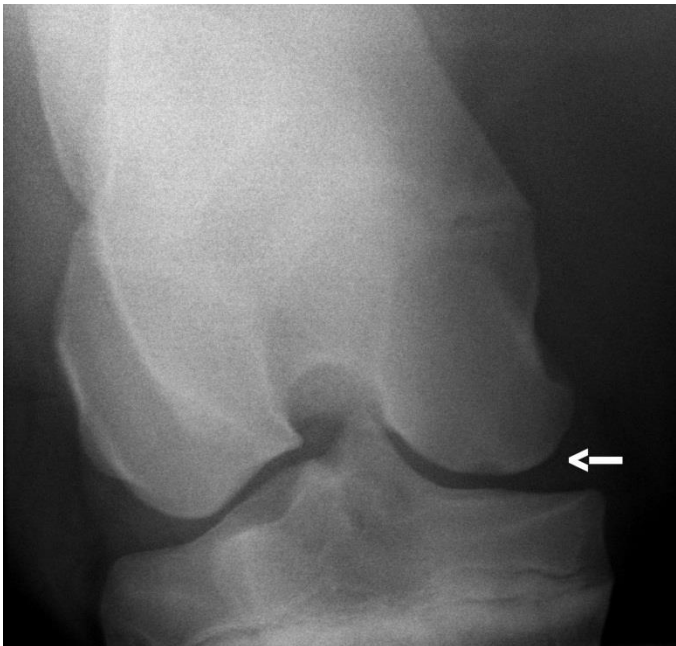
Caudoproximal 30° craniodistal oblique radiographic view of stifle showing a small, well demarcated subchondral bone cyst (arrow) in the middle of the medial femoral condyle.
